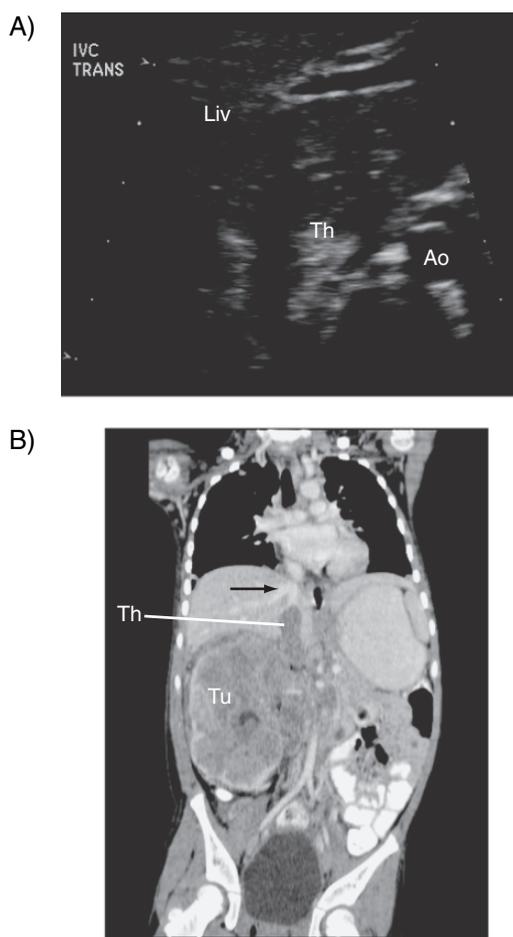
(A) Ultrasound showing cross-sectional view of the liver (Liv), inferior vena cava (IVC) tumor thrombus (Th) extending from primary tumor, and the aorta (Ao). (B) Coronal reconstruction CT scan showing tumor thrombus (Th) extending from the right kidney primary tumor (Tu) into the IVC. Distal to the thrombus, the patent hepatic vein and IVC (black arrow) can be seen draining into the right atrium.
